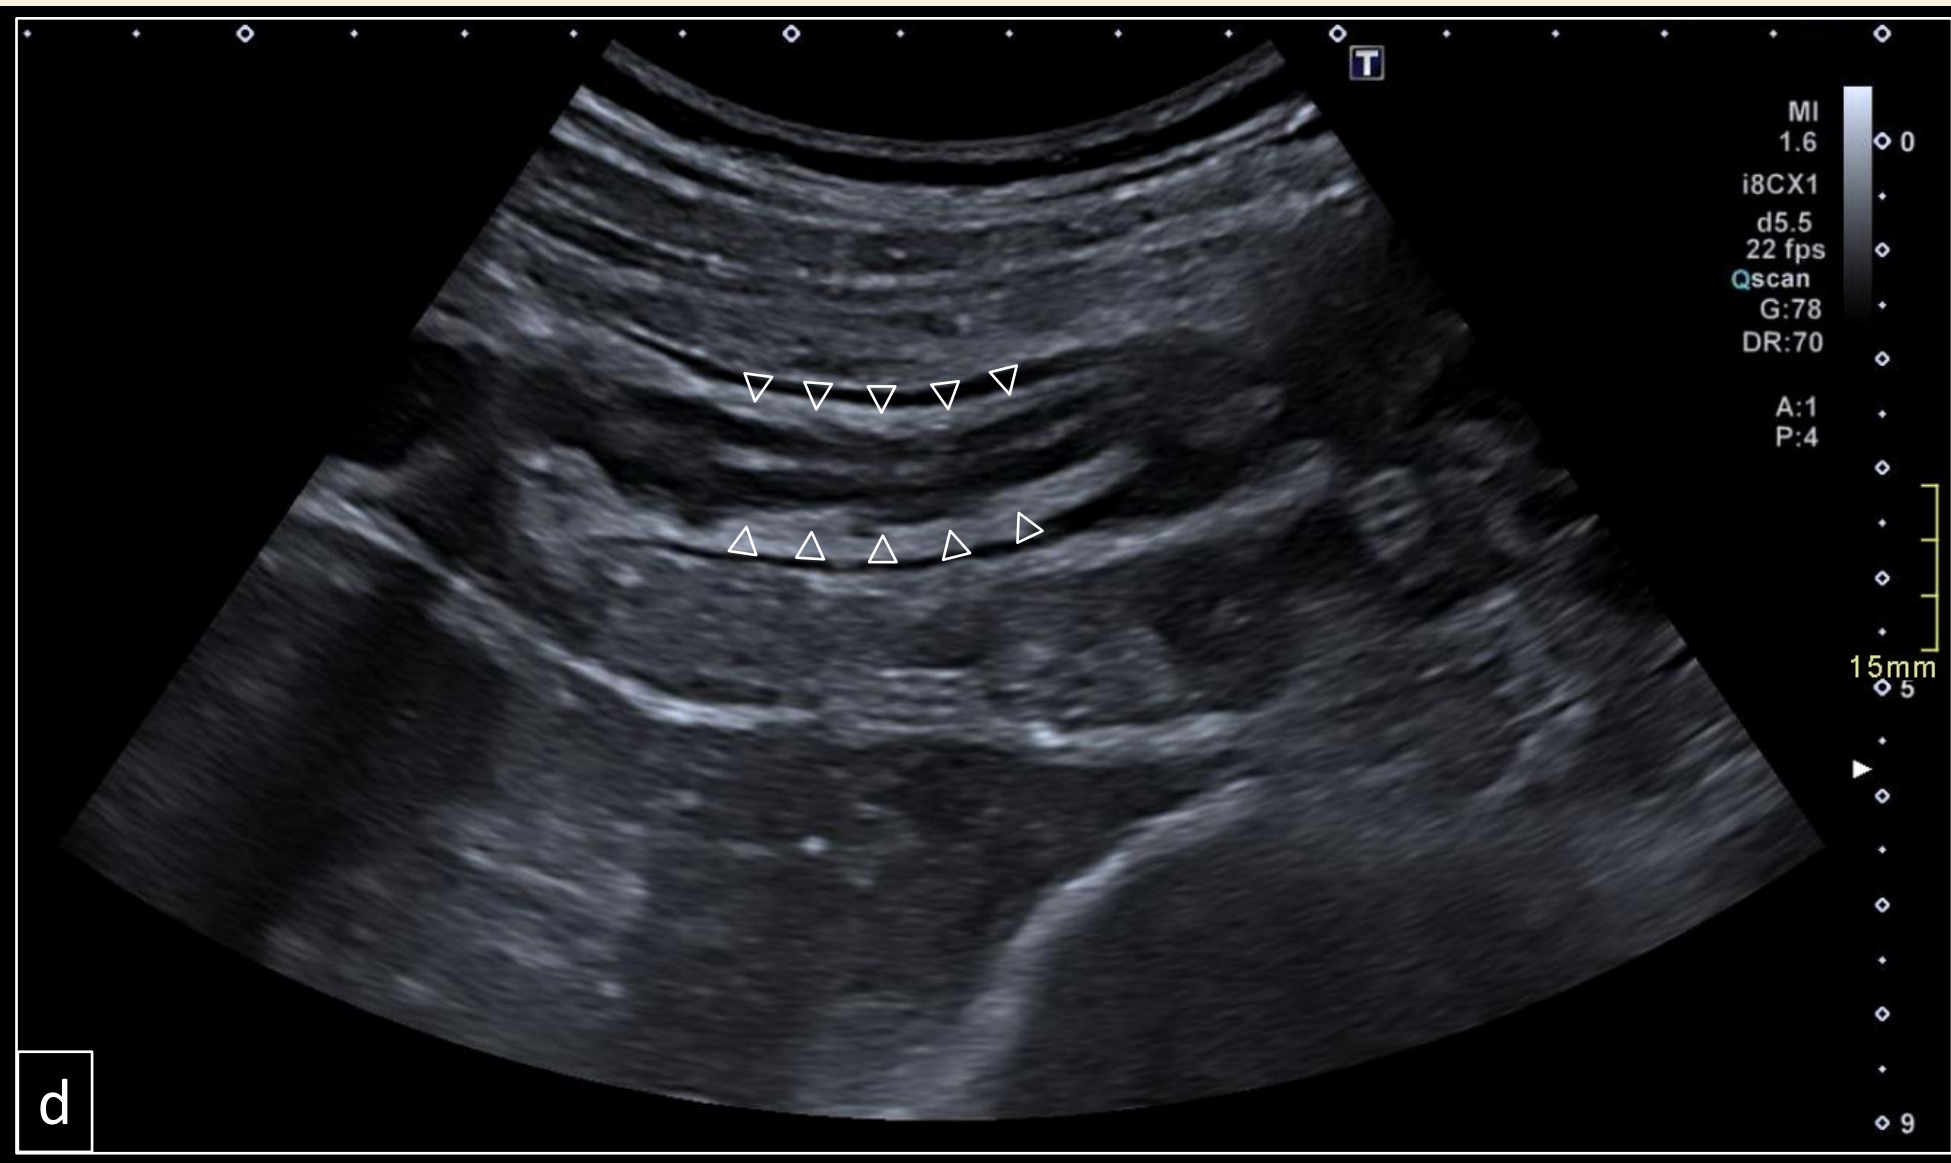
(a-d): Contrast-enhanced CT of the abdomen in portal venous phase axial view (a) and sagittal oblique MPR reconstructions (b and c) showing small bowel obstruction (a, white double-headed arrow), intussusception of appendix with target sign (a, blue arrow), and a tubular hypervascular structure in the cecal lumen (b, c; green arrow), as well as inflammatory changes of the small and large intestine (b, c; white single-headed arrows). Initial ultrasound demonstrated a tubular structure in the cecal lumen (d, white arrowheads).
